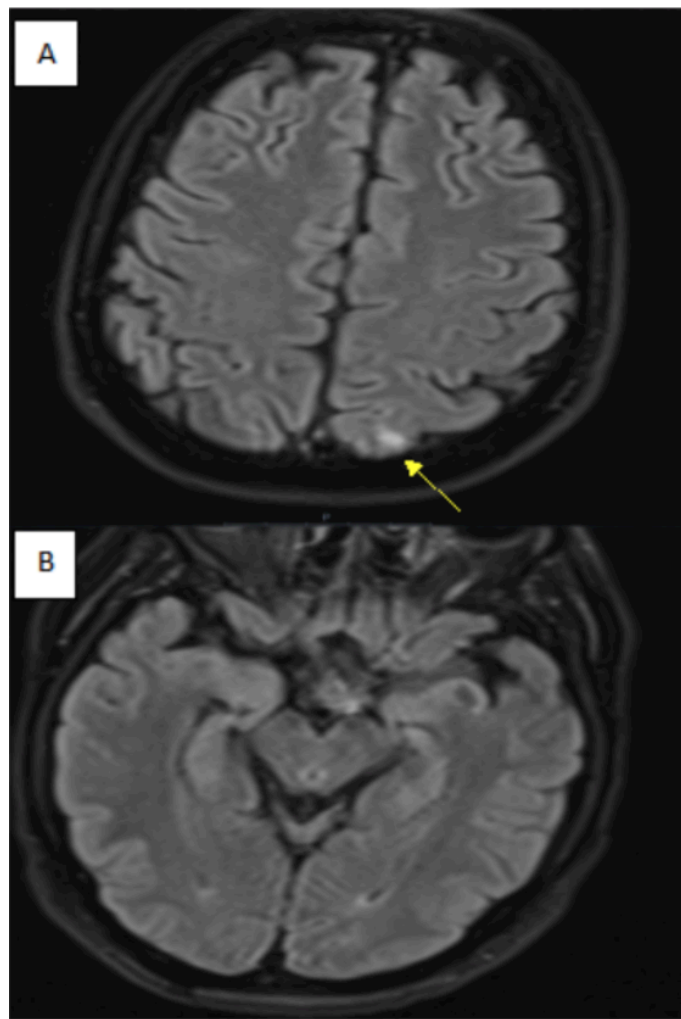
Follow-up magnetic resonance imaging (MRI) at 1 and 3 months. (A) MRI brain fluid-attenuated inversion recovery (FLAIR) imaging at 1 month showing almost complete resolution (yellow arrow) of parenchymal changes with no residual gliosis. (B) MRI brain FLAIR imaging at 3 months showing complete resolution of parenchymal changes.
